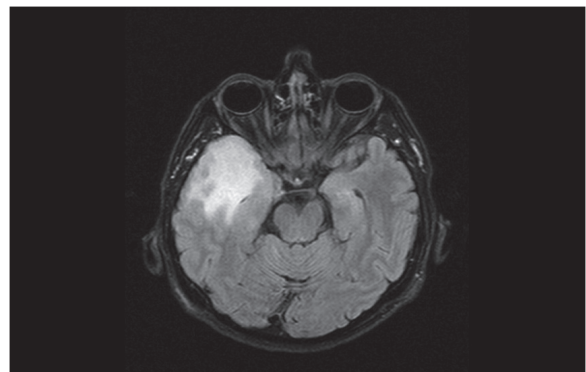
MRI before surgery. Axial T2-weighted FLAIR image show an extensive edematous area around the tumor in right temporal lobe
